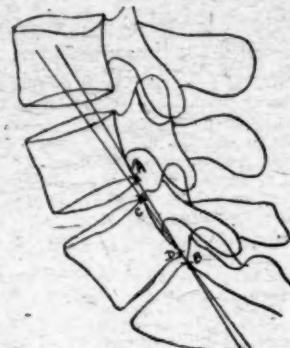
Tracing of a radiograph of a normal subject; the lines drawn intersect at the lower margin of the fifth lumbar vertebra.
